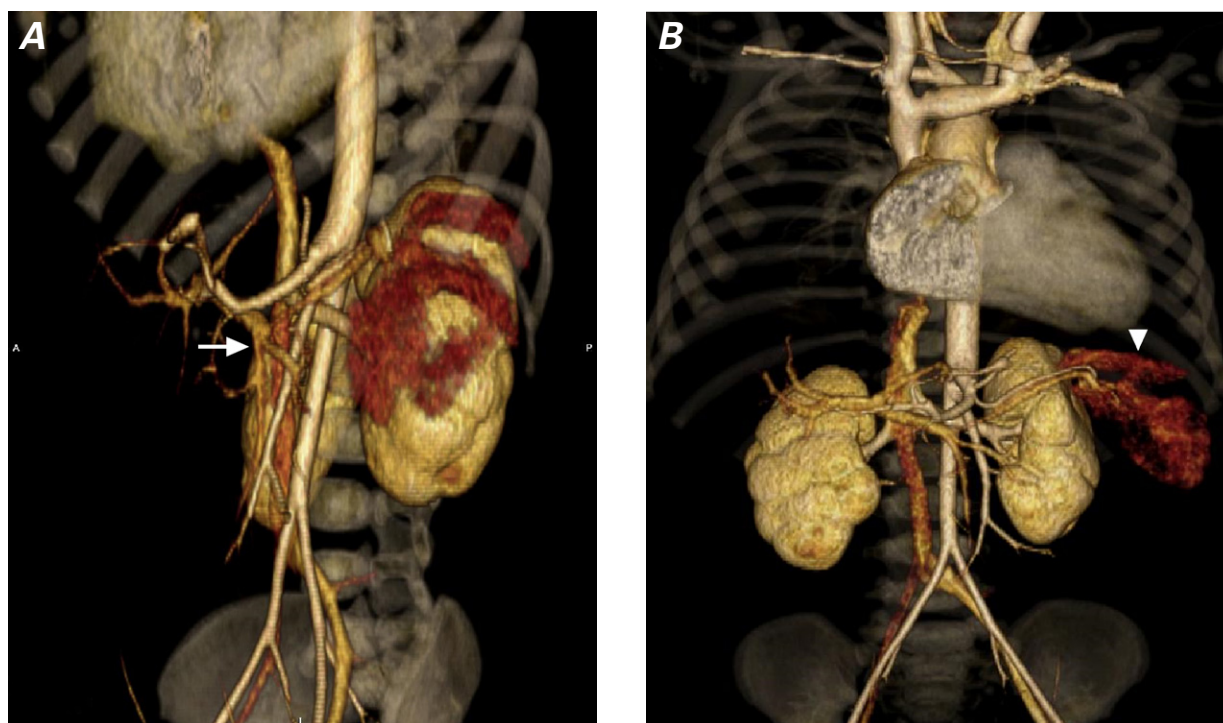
Four months later, computed tomograms (3-dimensional volume-rendered) in A) left lateral and B) anteroposterior views show that the left hepatic vein (arrow) draining the anomaly is still prominent, but that the vascular lesion itself (arrowhead) is markedly reduced in size.
